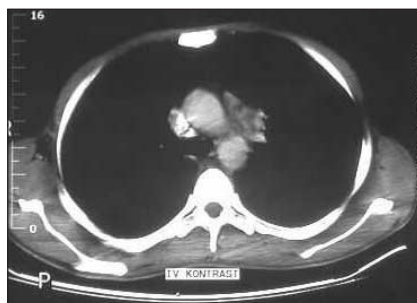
Computed tomographic image showing a tuberculoid mass in the lung, before mediastinoscopy.
